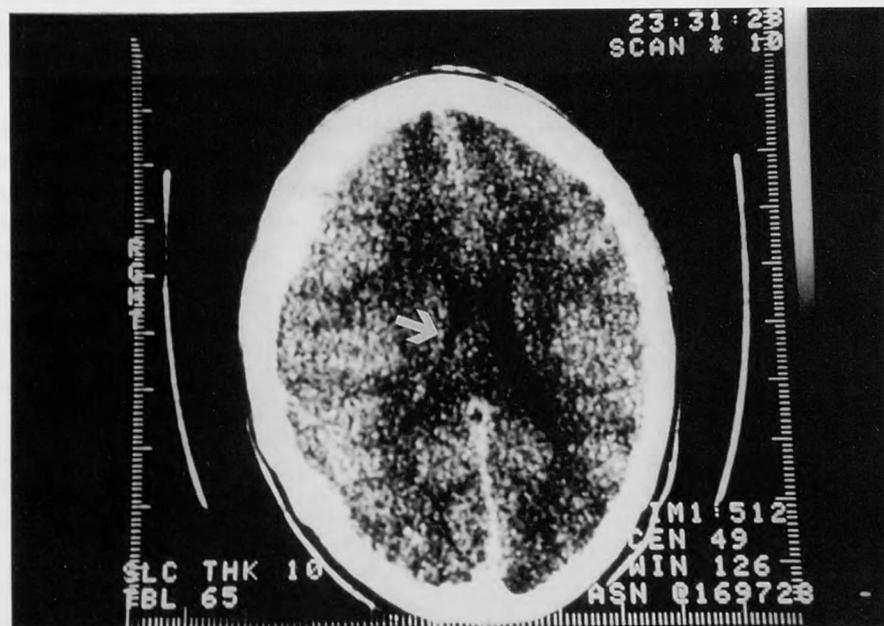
CT scan of October 18. Note the midline shift and collapsed ventricle. The subdural hematoma is located in the upper left corner.
